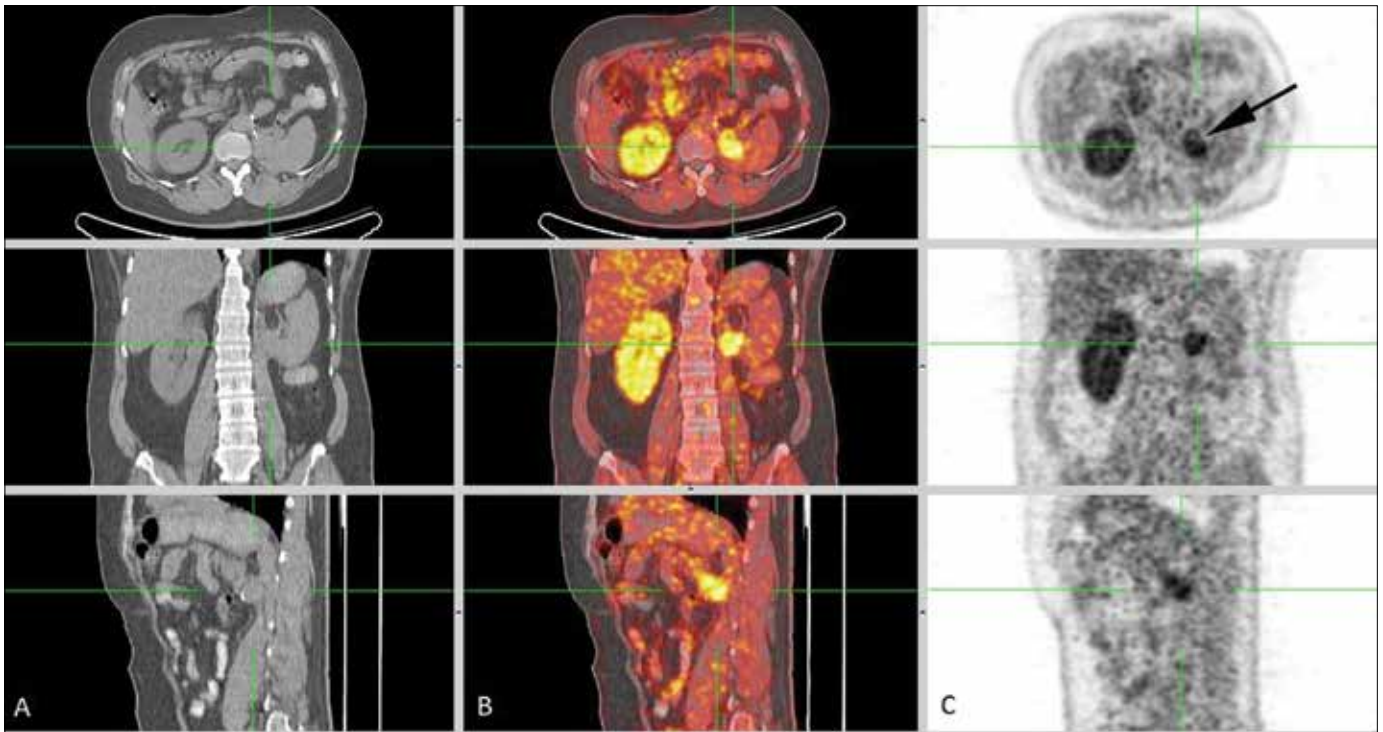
F-18-DOPA PET-CT: 3-axial view of the F-DOPA positive, recurrent tumor in the left paraaortic region with a maximum diameter of 5 cm. A: CT, B: PET-CT, C: DOPA-CT.
